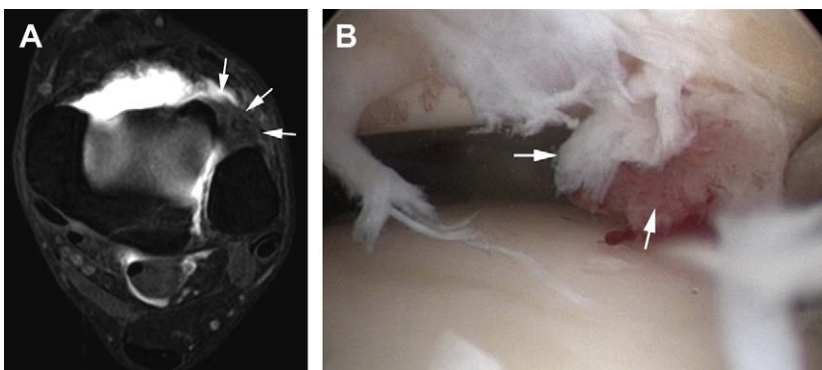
Anterolateral impingement syndrome. (A) Axial fat-suppressed T1-weighted spin echo MR arthrogram of left ankle demonstrates nodular irregular lesion surrounding inferior fascicle of AITF (Bassett's ligament) in the superior aspect of the anterolateral gutter (arrows). (B) Corresponding arthroscopic image showing focal fibrosis and synovitis (arrows) surrounding inferior fascicle of AITF.
